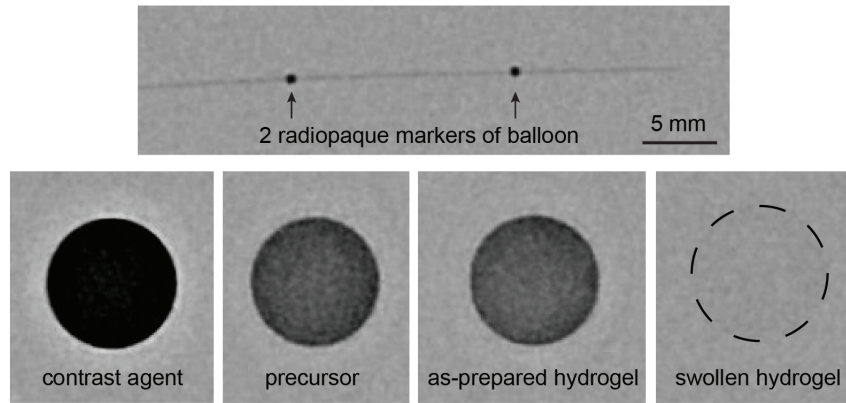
Radiography snapshot of a deflated balloon with its two proximal and distal radiopaque markers, pure contrast agent, hydrogel precursor, as-prepared hydrogel and swollen hydrogel.
